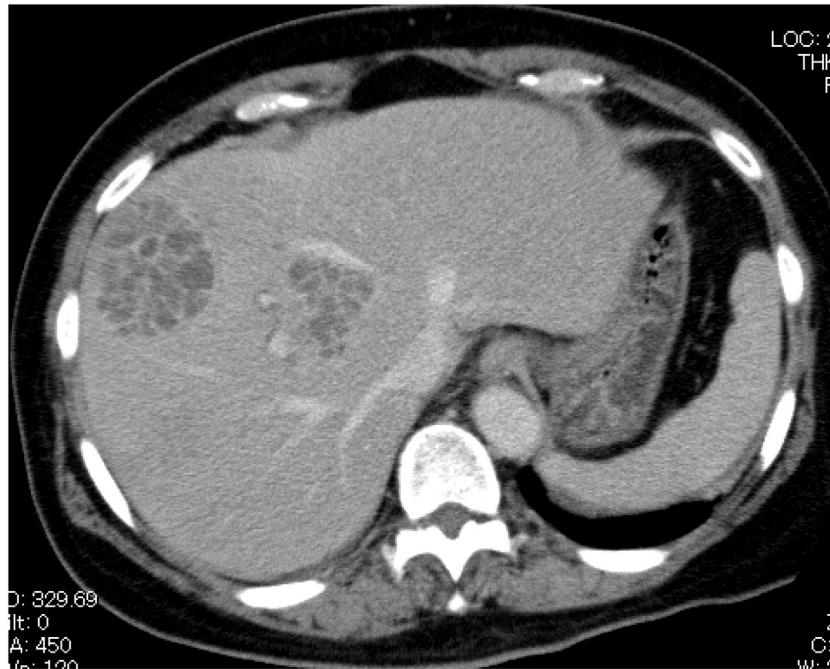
An abdominal computed tomography with contrast enhancement showed multiple multiloculated abscesses in right hepatic lobe (max diameter: 14 cm).
